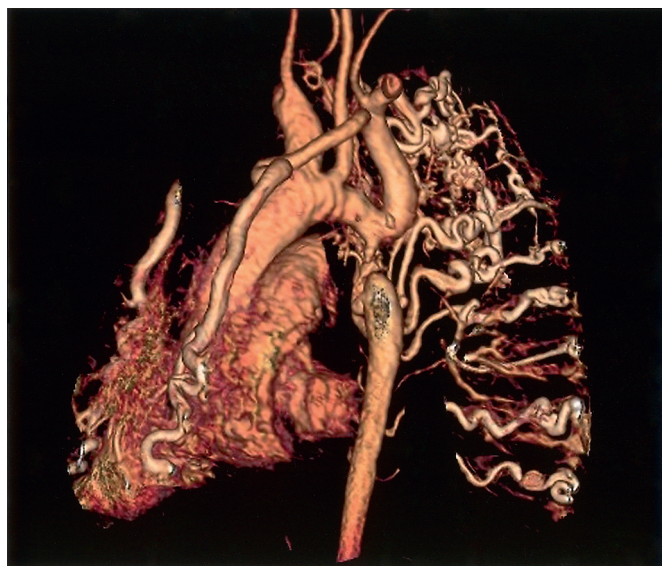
Magnetic resonance imaging scan of the heart obtained in a 34-year-old woman with severe coarctation of the aorta (near interruption), with multiple very large collateral vessels. She had had two previous pregnancies with preeclampsia, and the coarctation had gone unnoticed.
